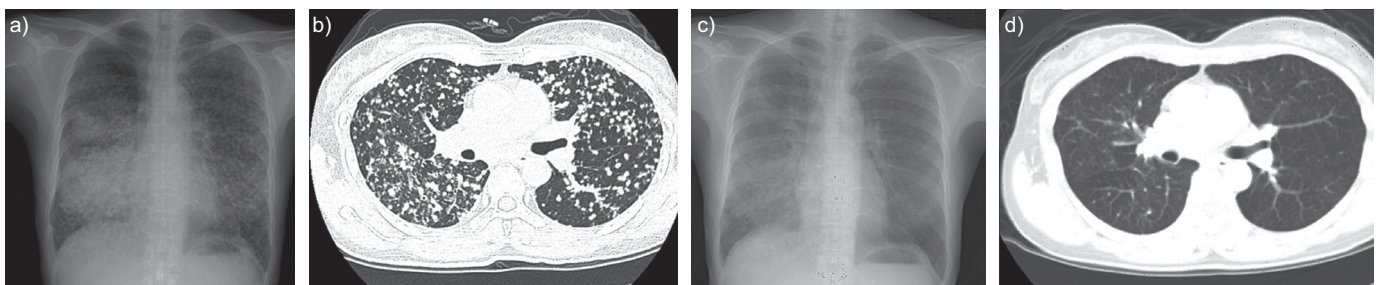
a, c) Chest radiography and b, d) computed tomography showing a patient a, b) with miliary intrapulmonary carcinomatosis at initial diagnosis. c, d) After treatment with the epidermal growth factor receptor tyrosine kinase inhibitor gefitinib for 2 months, the images showed an obvious decrease of the miliary lung metastases.
